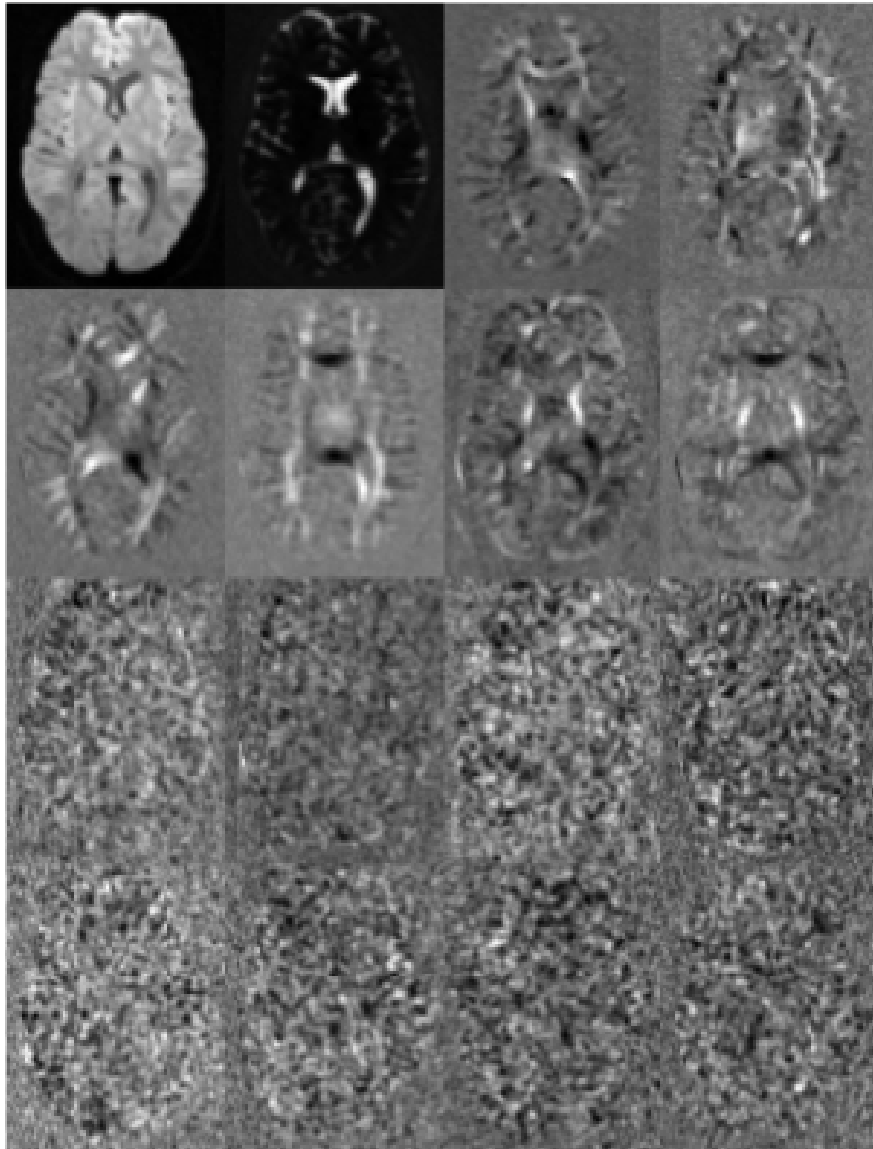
PCA decomposition of the registered DWI dataset (first 16 components). Images are displayed in order of decreasing variance, starting from the top left. Image variance around the edges of the brain, and in CSF-white matter interfaces, seems to be reduced in the third and fourth components.
